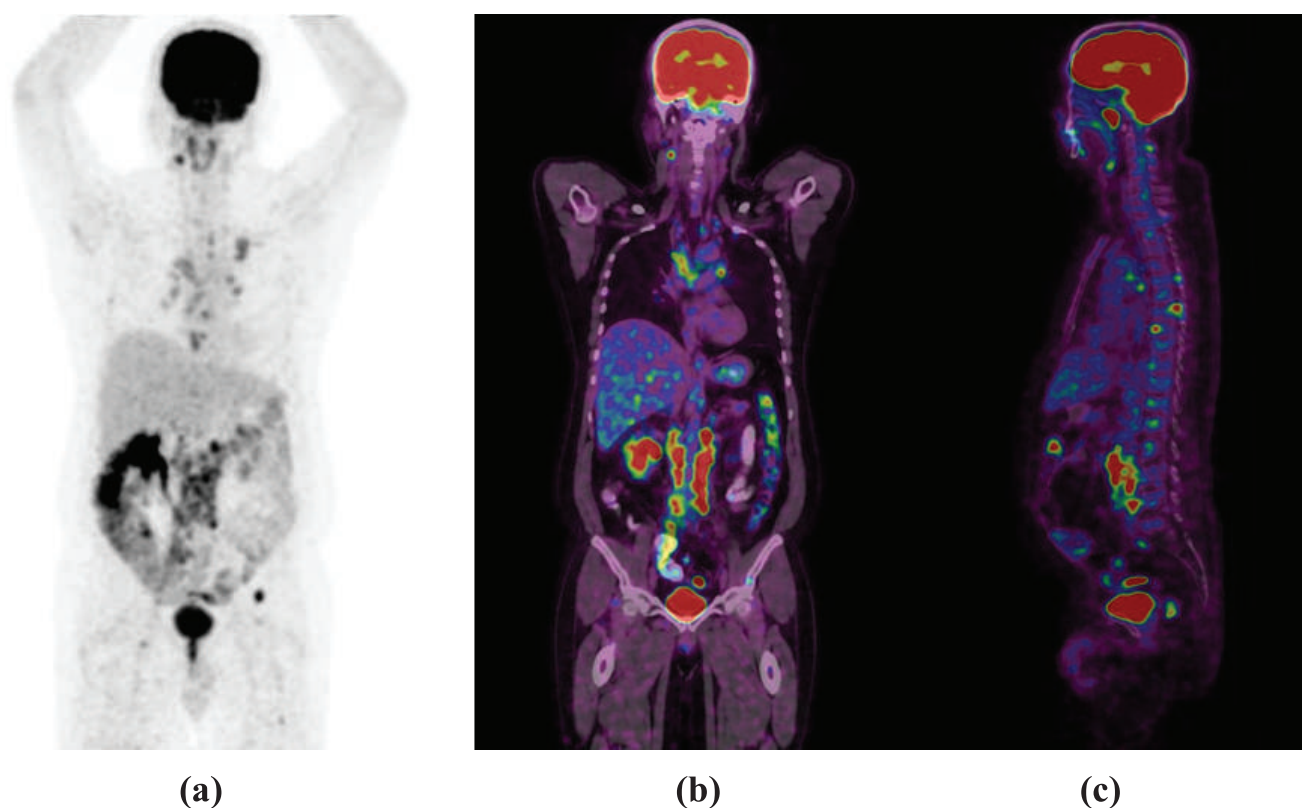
Maximum intensity projection (a), coronal (b) and sagittal (c) ^{18}F FDG PET-CT images show hypermetabolic activity in multiple regions, including the cervical, mediastinal, and abdominal lymph nodes, as well as skeletal lesions.
